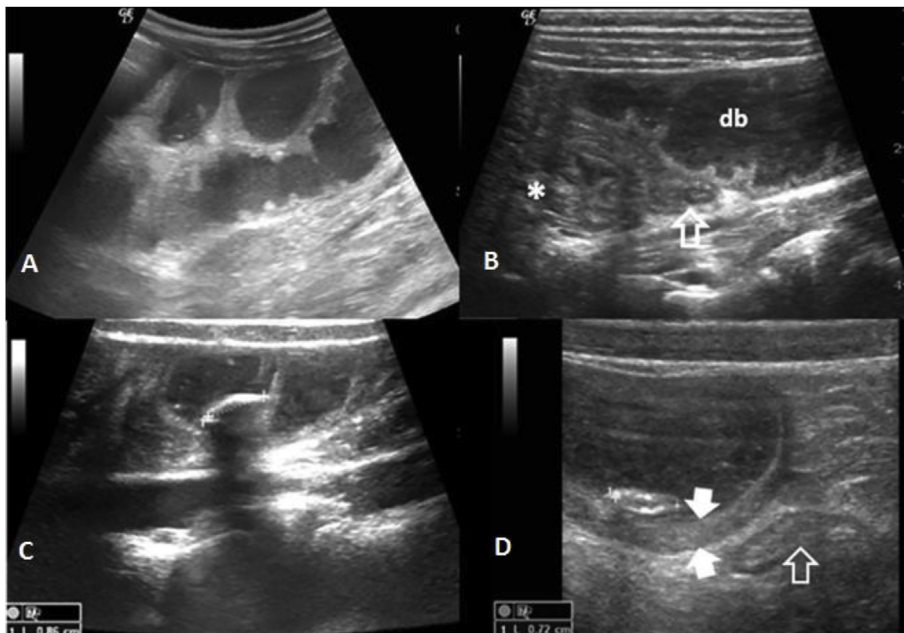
Ultrasonography requested for non-specific abdominal pain.
